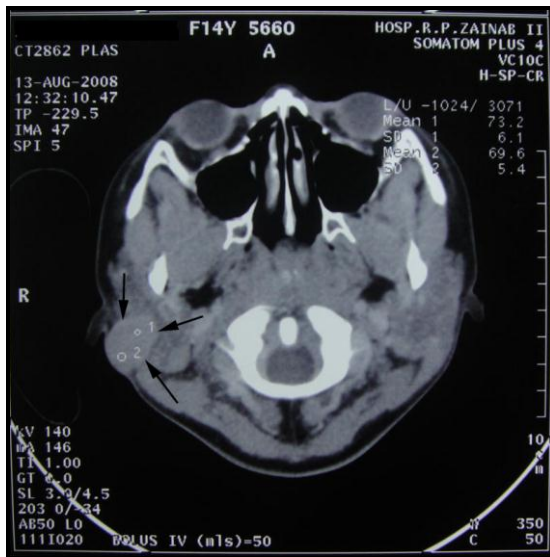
Axial view of CT scan showed a well defined round homogeneously enhancing lesion in the superficial lobe of the right parotid gland posterior to the right auricle.
